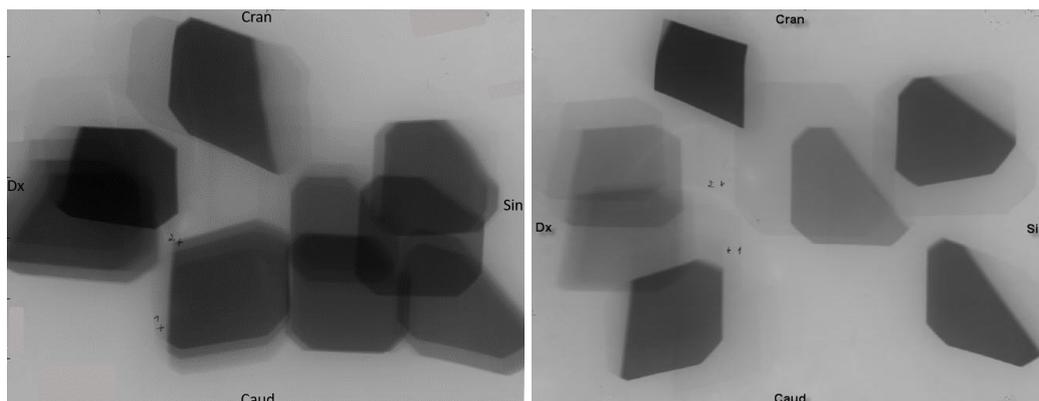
Skin exposure maps (radiographic films) from two patients that underwent coronary angiography procedures, performed by two different operators (left panel, operator A, 2 years of experience; right panel, operator B, 10 years of experience).
